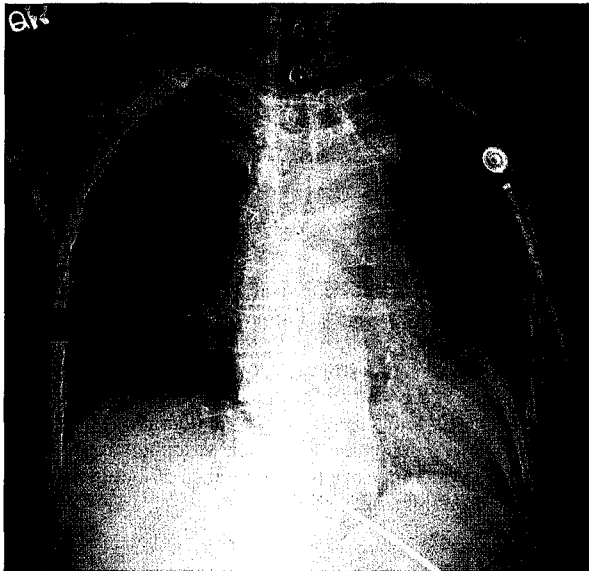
Chest radiography shows cardiomegaly and right pulmonary artery engorgement (arrow). A widened mediastinum is also noted.
